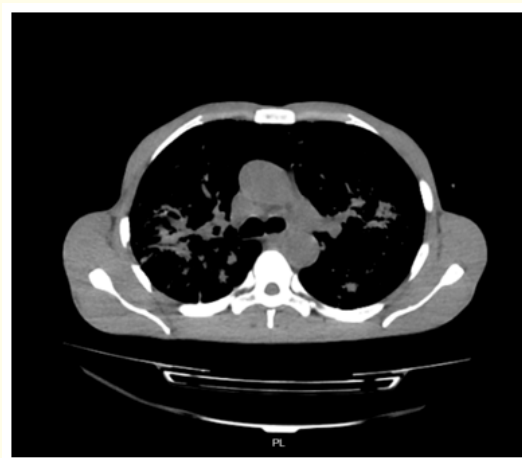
High-resolution computed tomography of the lungs.
